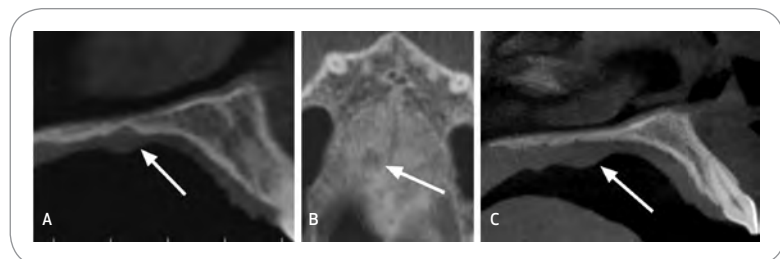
Mucoepidermoid carcinoma of the hard palate. Data acquired using an iCAT CBCT machine. Images were reformatted in iCATVision software. A and B are from the same patient. Arrows show areas of the tumor. Arrows on panels A and C show small soft-tissue growth. Arrow in panel B shows small area of bone resorption.
